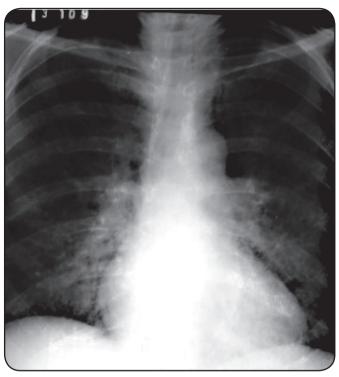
Routine anteroposterior chest X-ray showing a diffuse interstitial infiltrate.
